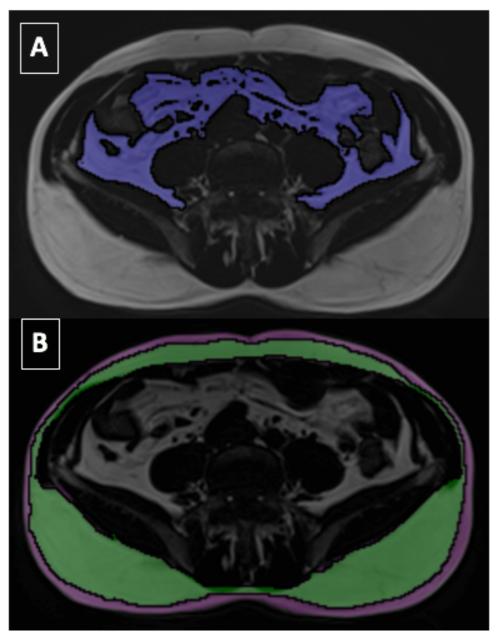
An axial MRI image at the L4-5 anatomical position showing the highlighting of VAT (blue), A; and highlighting of dSAT (green) and sSAT (magenta), panel B.
